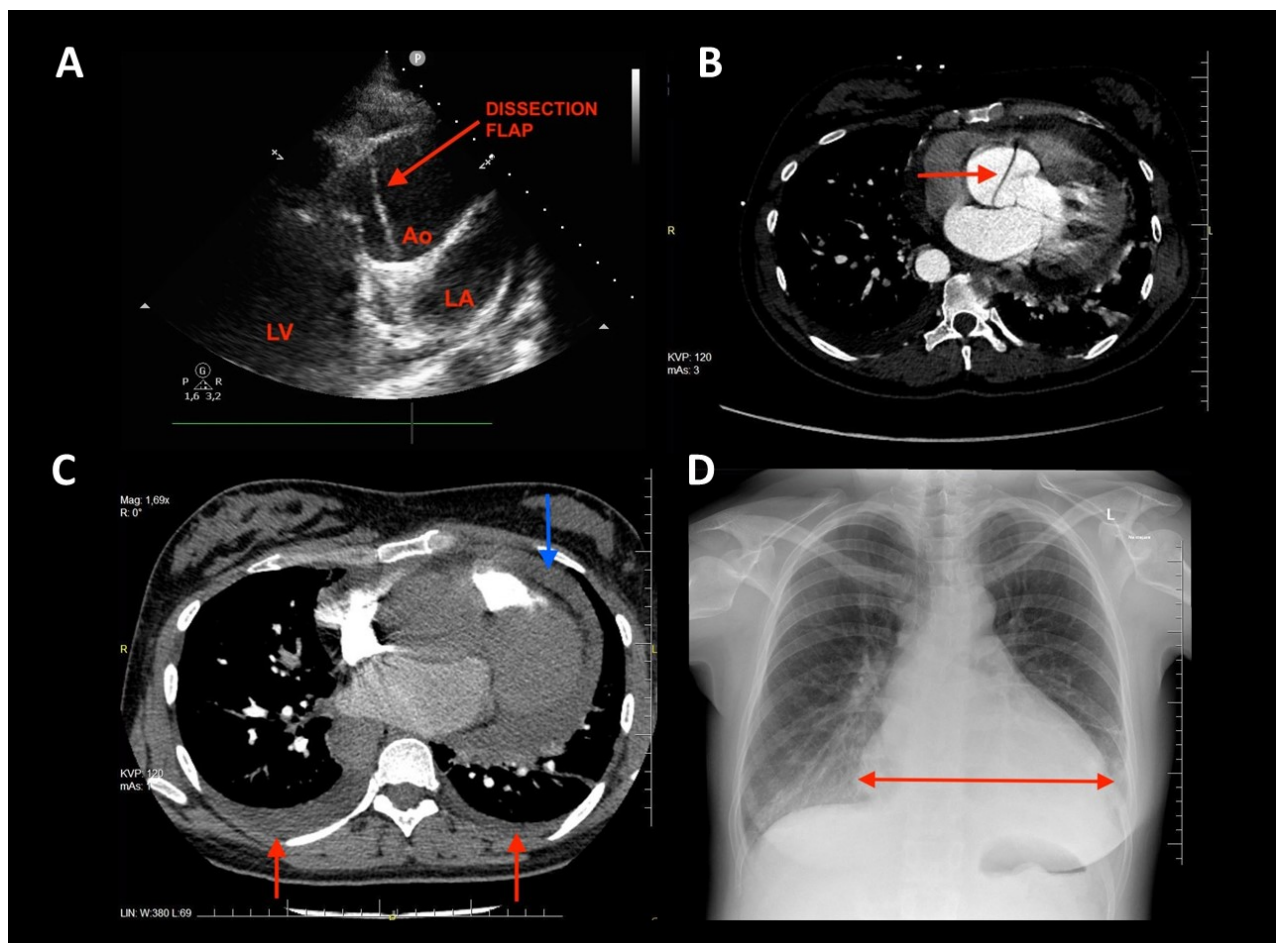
A. Echocardiography showing Stanford type A aortic dissection — dissection flap (red arrow), left atrium (LA), left ventricle (LV), aortic root (Ao); B. Chest computed tomography (CT) — type II De Bakey aortic dissection (red arrow); C. Chest CT — fluid in the pericardial sac (blue arrow) and both pleural cavities (red arrows); D. Chest X-ray — enlarged cardiac silhouette
